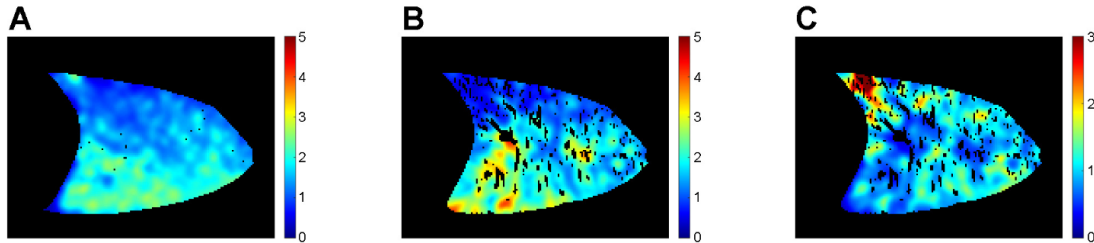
Figure extracted from Sà *et al.* work⁹⁷ using oxygen-enhanced MRI. Maps of the alveolar ventilation V_a (A), perfusion Q (B), and V_a/Q ratio (C) in a sagittal slice of the right lung in a healthy volunteer lying in the supine position. V_a and Q are expressed in ml/min/ml of lung. Ventilation-perfusion matching mainly occurs in the posterior dependent regions.
